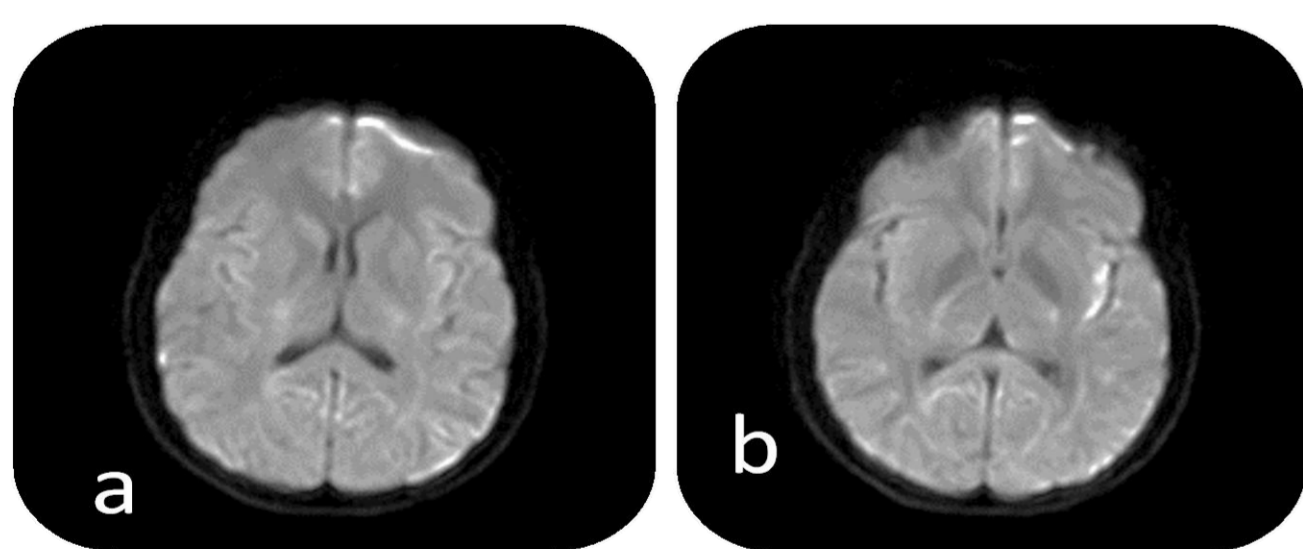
Brain MRI showed no abnormality on the non-contrast-enhanced sequences (including susceptibility weighted imaging [SWI], T1, and T2-weighted FLAIR), but the diffusion weighted imaging (DWI) shows restricted diffusion with high signal on the left hemisphere mainly in the cerebral cortex with a gyro morphology.
